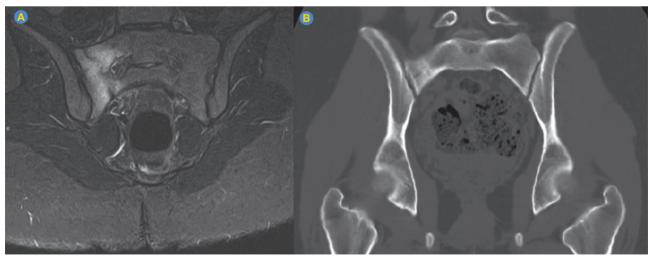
Coronal section of MRI (at diagnosis) where a trace of vertical fracture (parallel to the sacroiliac joint) is observed along the anterior cortical of the right wing of the sacrum, associated with bone marrow edema, without reaching the posterior surface of the sacrum (A). Coronal section of CT that revealed mild sclerosis of the right wing of the sacrum (exam performed four weeks after symptom onset) (B).
